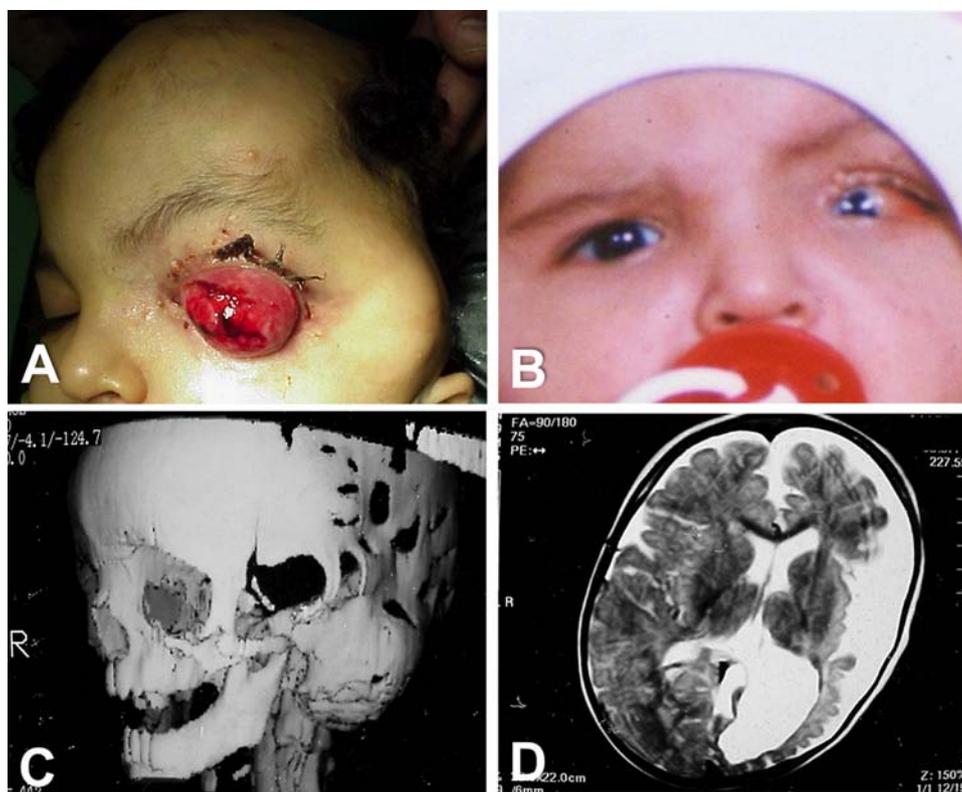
A, External photo shows large, fleshy mass protruding from the left eye in a patient exhibiting left frontoparietal alopecia, faint scalp nevus, multiple eyelid and periocular skin tags, and subcutaneous temporal lipoma. B, Photograph of patient at age 10 months showing left eye esotropia, hazy cornea, and a flat red lesion on the temporal conjunctiva. C, Three-dimensional computed tomographic scan shows multiple skull defects. D, Magnetic resonance imaging shows atrophy of the left cerebral hemisphere and widening of the left lateral ventricle.
